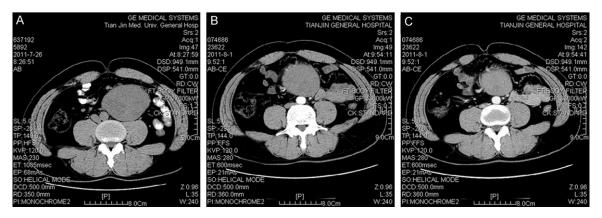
Abdominal CT scan demonstrated well-defined and large mass within the abdominal cavity. Pre-contrast imaging showed an unequal density distribution with relative hypo-attenuation of the mass (A). Arterial Phase showed inhomogeneous well defined mass with extensive vascular communication (B). Venous Phase showed the mass with delayed enhancement (C).
